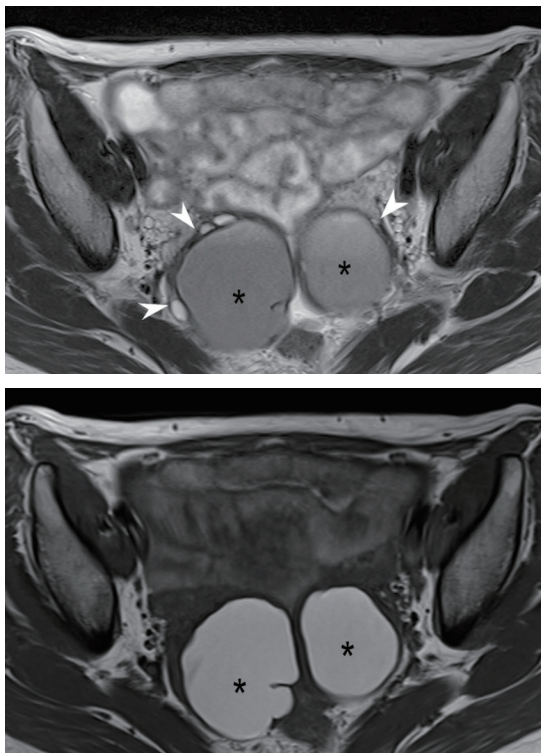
Initial pelvic MRI for the ovarian masses.
